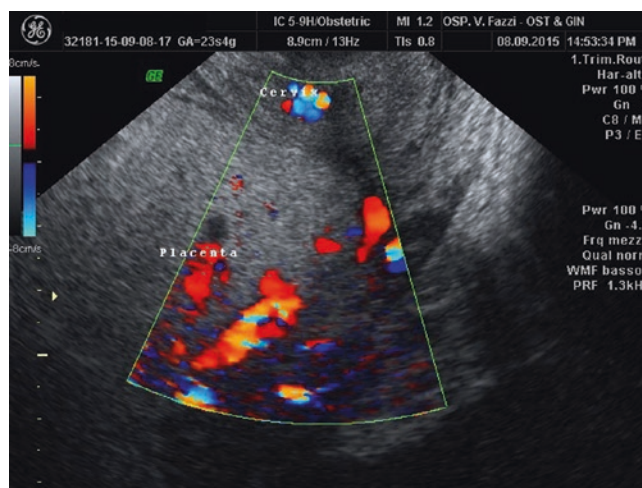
A transvaginal ultrasonographic scan of central placenta previa with accretism
